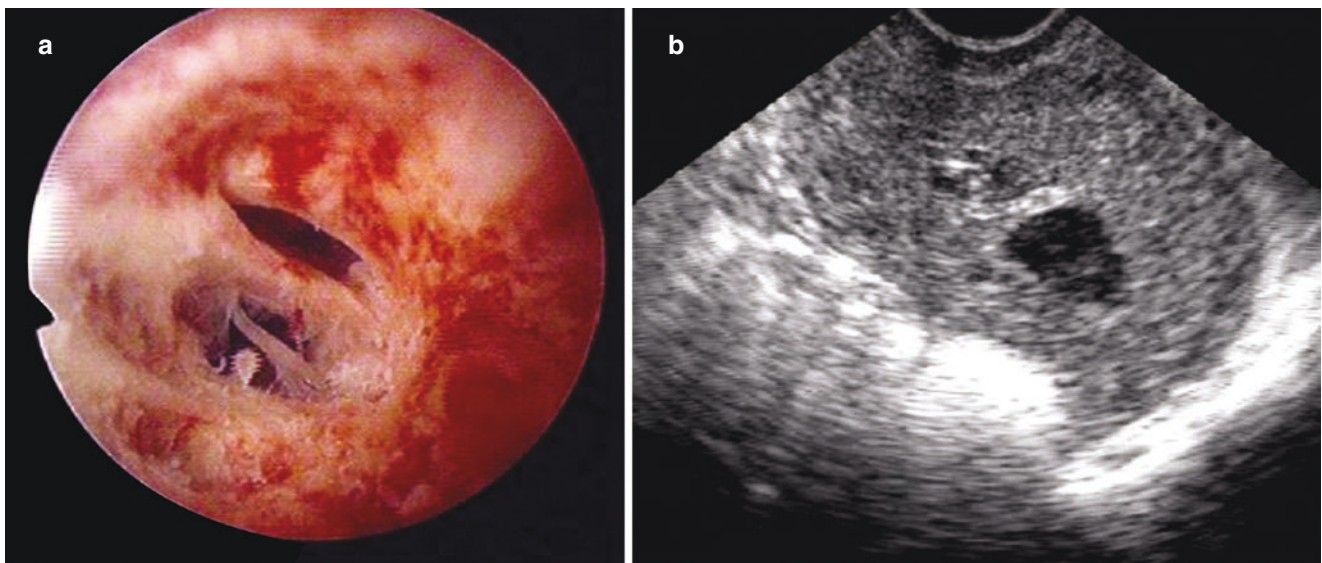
uterine adhesion combined with hematocoele. (a) hysteroscopic image of uterine adhesion. (b) ultrasonography shows the adhesion bands and hematocoele in the uterine cavity
